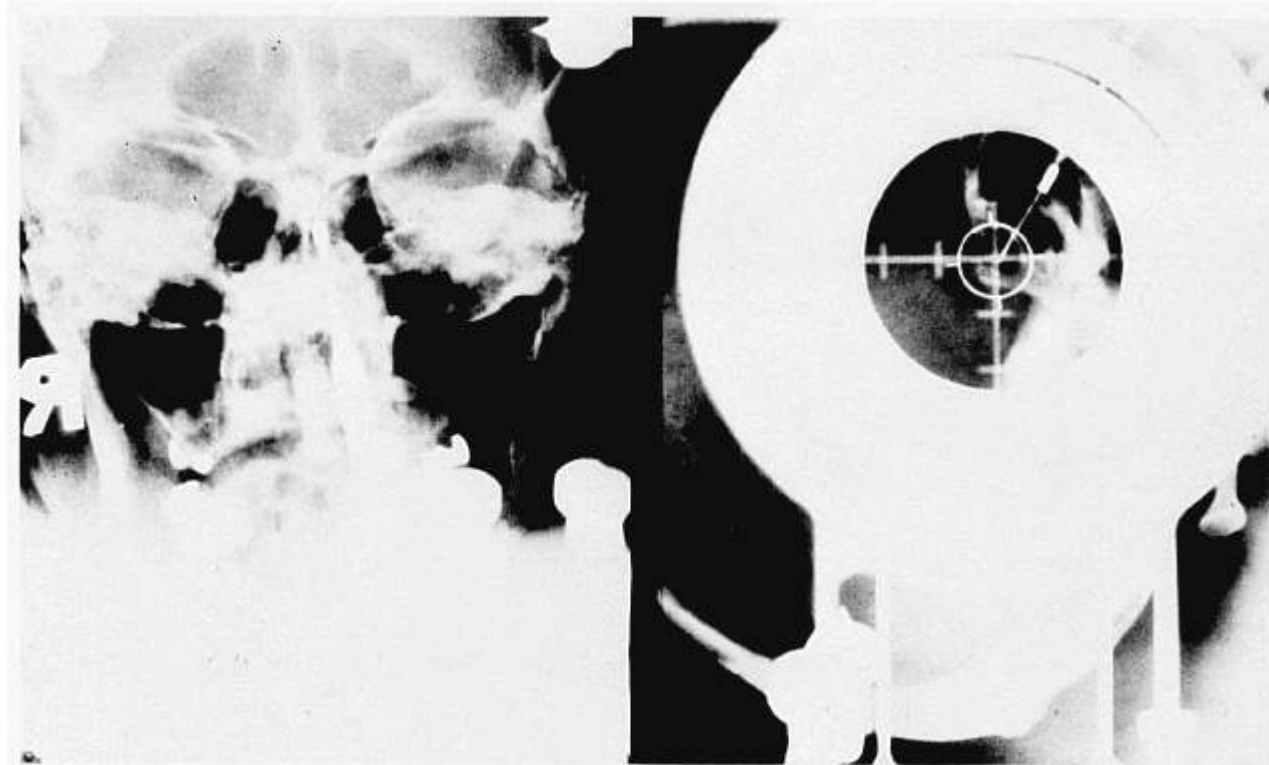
Radiograph showing A-P and lateral views of spinal needle at target in sella.
